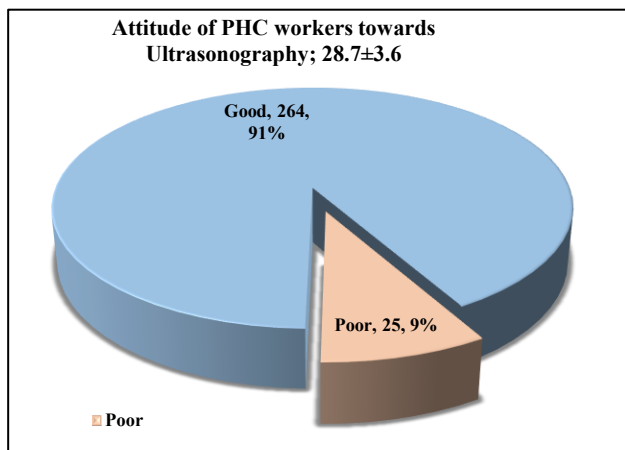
Attitude towards basic obstetric ultrasound service provision among PHC workers
